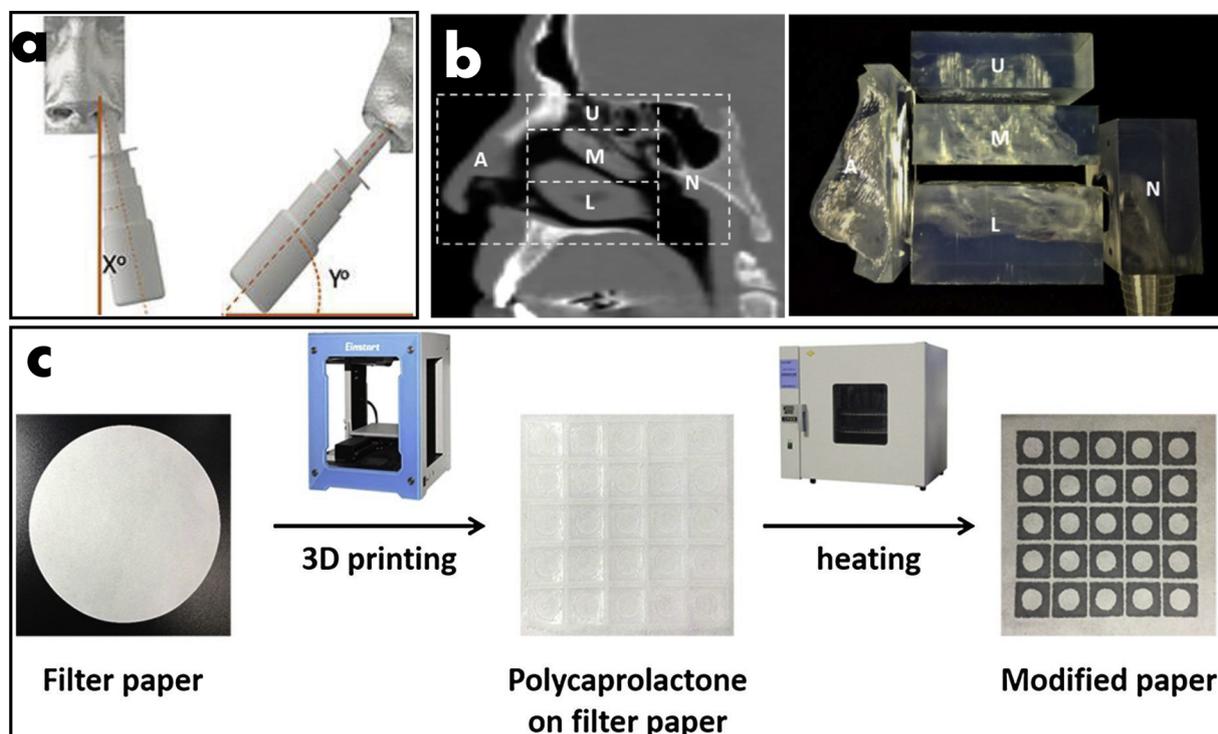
3D printing of acellular models. (a) Measurement of optimal angle for nasal spray administration. (b) CT scan and 3D printed model of adult nasal passage. (c) Preparation of paper-based analytical devices prepared with polycaprolactone.
